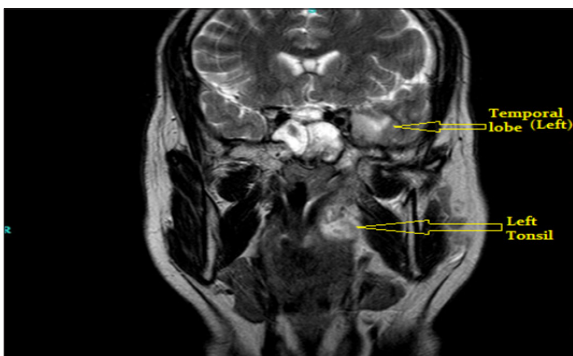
A Radiological Representation (T2 Weighted MRI) of the Same Patient Showing Increased Intensity at Left Paratonsillar Region and Left Temporal Lobe. There was no Palatal or Paranasal Sinus Involvement
